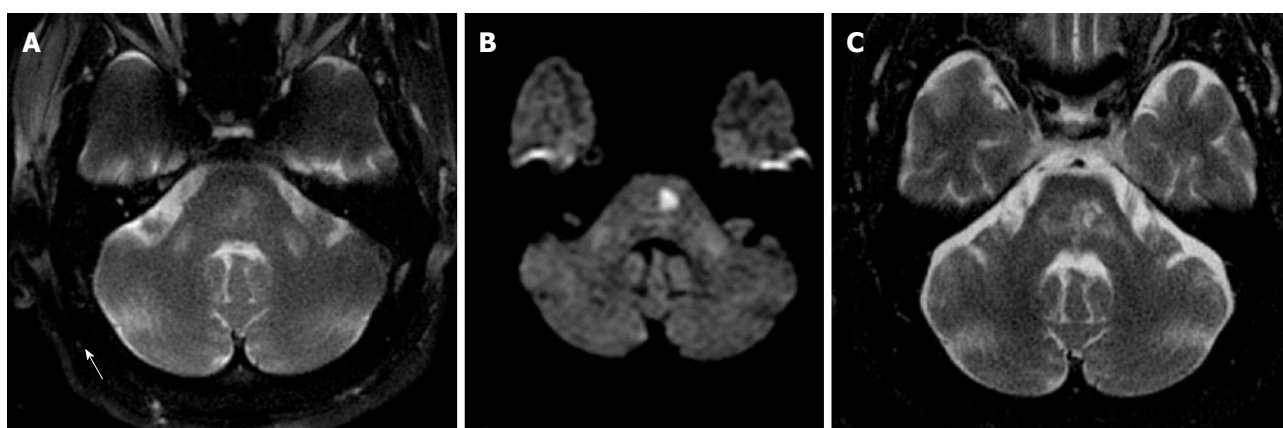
Wallerian degeneration of middle cerebellar peduncles. Axial T2 (A) and DWI (B) images show symmetric areas of abnormal signal in bilateral MCP as well as focal area of restricted diffusion in the left pons (note the characteristic spore of the midline due to occlusion of para-median branches of basilar artery); Axial T2 (C), 3 years f/u, shows evolution of lacunar infarction in the pons with resolution of abnormal signal in the right MCP and persistent abnormal signal and development of volume loss in the left MCP. Findings are consistent with WD of the MCP, with “acute” early changes in the bilateral MCP and subsequent left greater than right involvement on follow up (ipsilateral to infarct). WD: Wallerian degeneration; MCP: Middle cerebellar peduncles.
